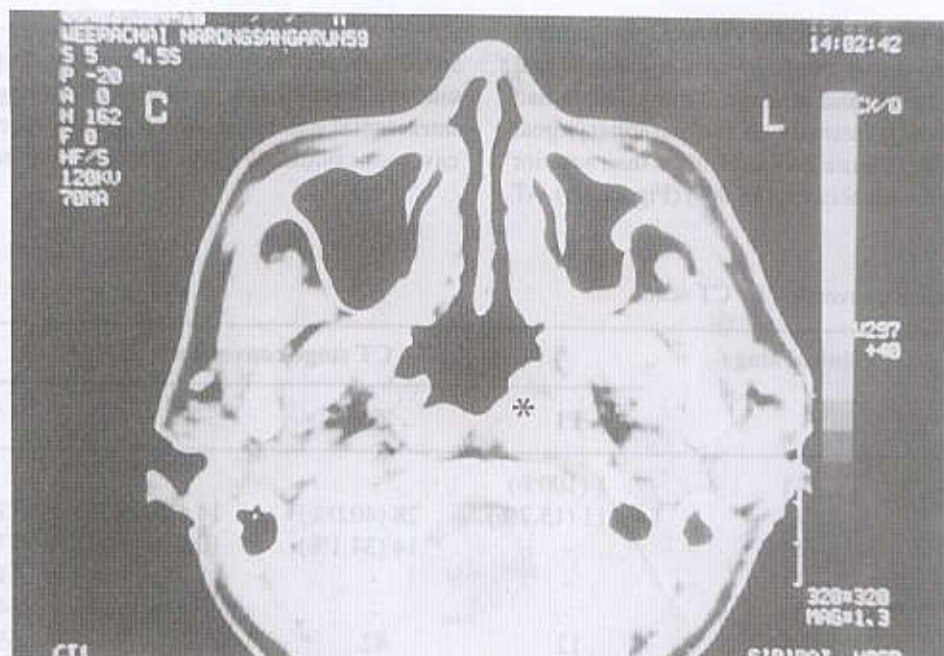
Axial CT scan of CA nasopharynx showing asymmetrical blunting of the left Rosenmuller fossa (stage T1).
